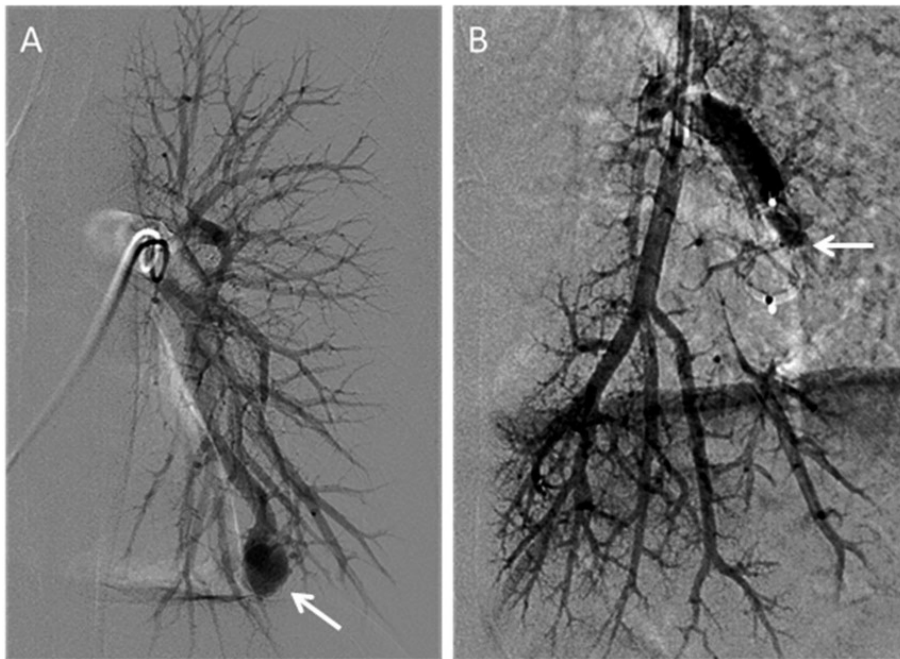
Pulmonary angiogram and embolisation in a patient with a PAVM in the left lower lobe on chest CT; A: Angiogram with pigtail in the left main pulmonary artery, showing a large PAVM (arrow) in the left lower lobe; B: Selective angiogram following embolisation, showing successful occlusion of the feeding artery after placement of an Amplatzer vascular plug (arrow).
